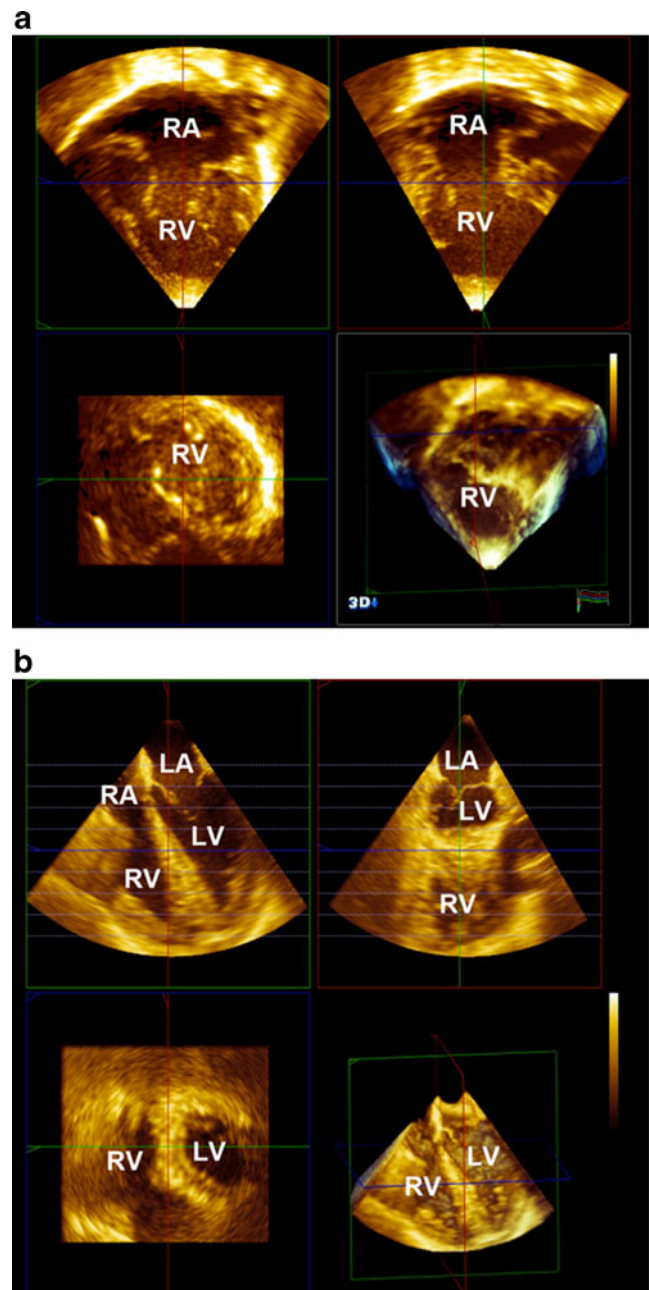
3-dimensional echocardiography of a patient with hypoplastic left heart syndrome by transthoracic approach (a) and in a normal subject by transesophageal approach (b). In each box, images include the apical view (top left), 2-chamber view (top right), axial view (bottom left), and pyramidal full volume of the heart (bottom right)
